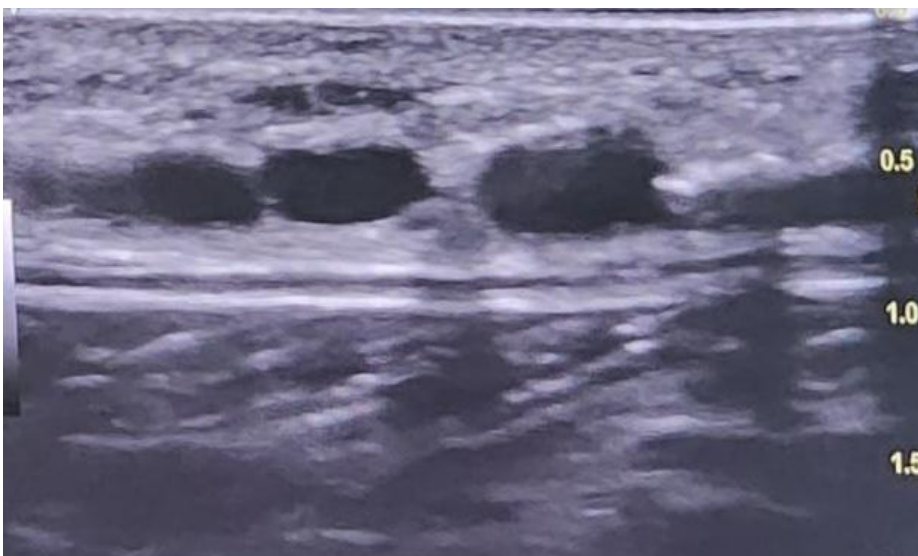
Ultrasound image confirming needle position into the small saphenous vein prior to sclerotherapy.
